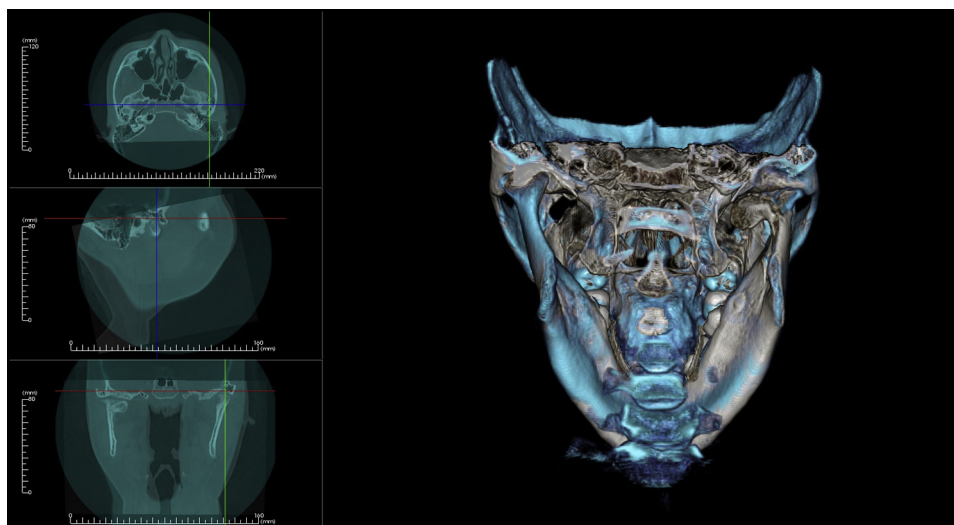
Superimposed 3-dimensional CBCT images showing remodeling of the fractured mandibular right condyle.
